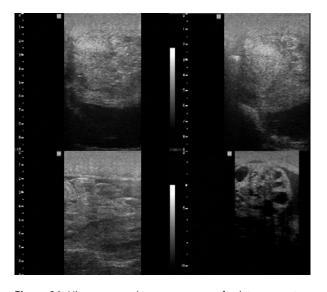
Ultrasonographic appearance of a leiomyoma in a mare.
